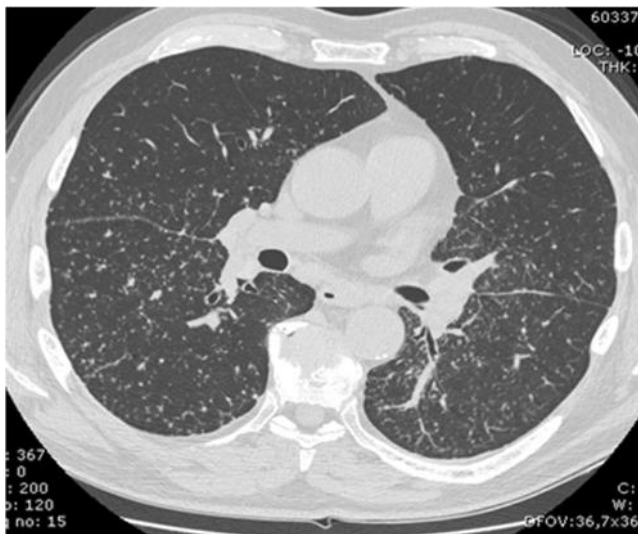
Sarcoidosis. CT scan showing small pulmonary nodules of homogeneous size and without an obvious perilymphatic distribution, thus mimicking miliary tuberculosis. However, a more careful inspection allows one to identify a subtle fissural involvement, a pattern of nodules distribution more in keeping with sarcoidosis
